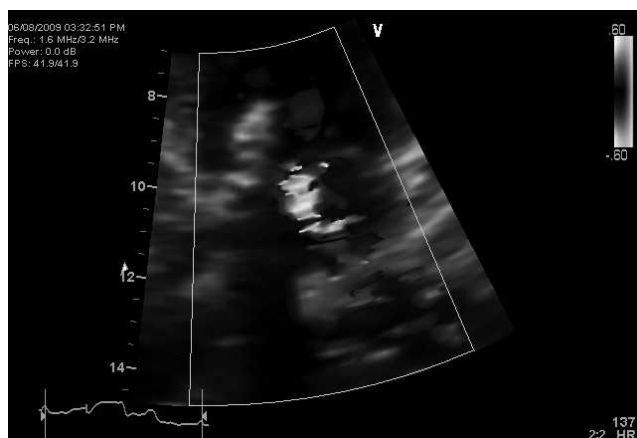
2-dimensional echocardiogram with Doppler ultrasound.
